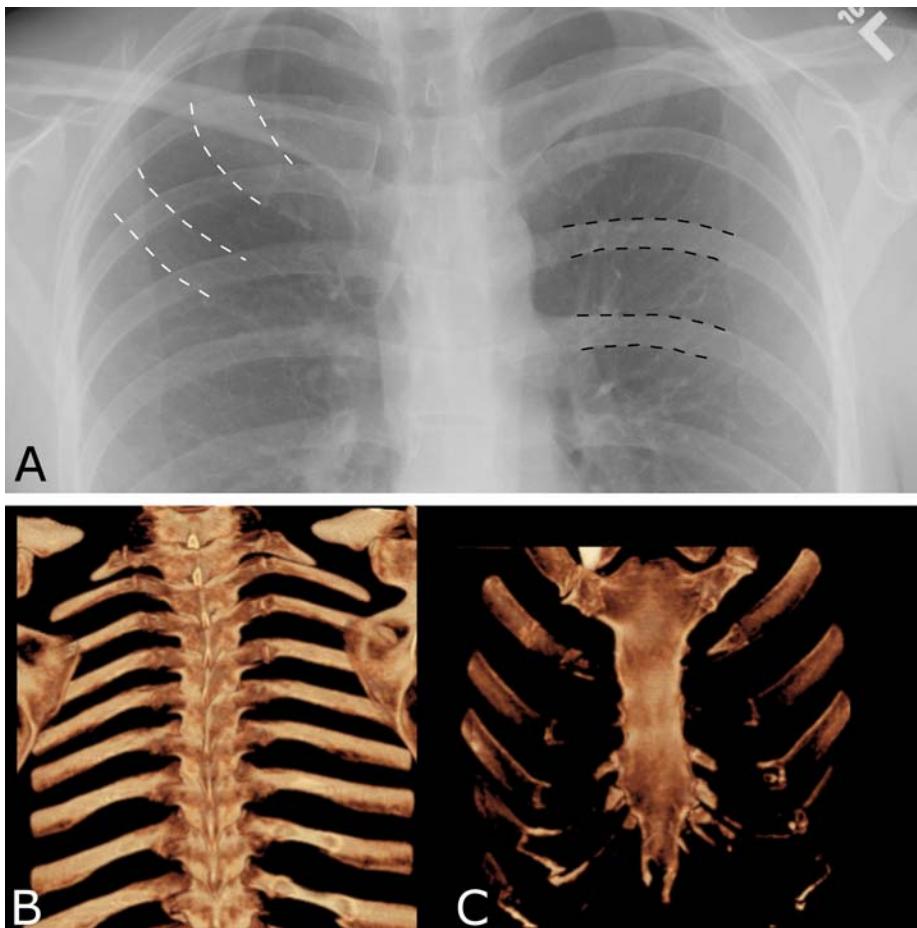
Ribs. A. Frontal radiograph shows that the posterior ribs (outlined in black) have a horizontal course, while the anterior ribs (outlined in white) have a more sloping course as they move medially. The anterior ribs are generally not seen as well as the posterior ribs. B. Posterior ribs on volume rendered CT. C. Anterior ribs on volume rendered CT.
